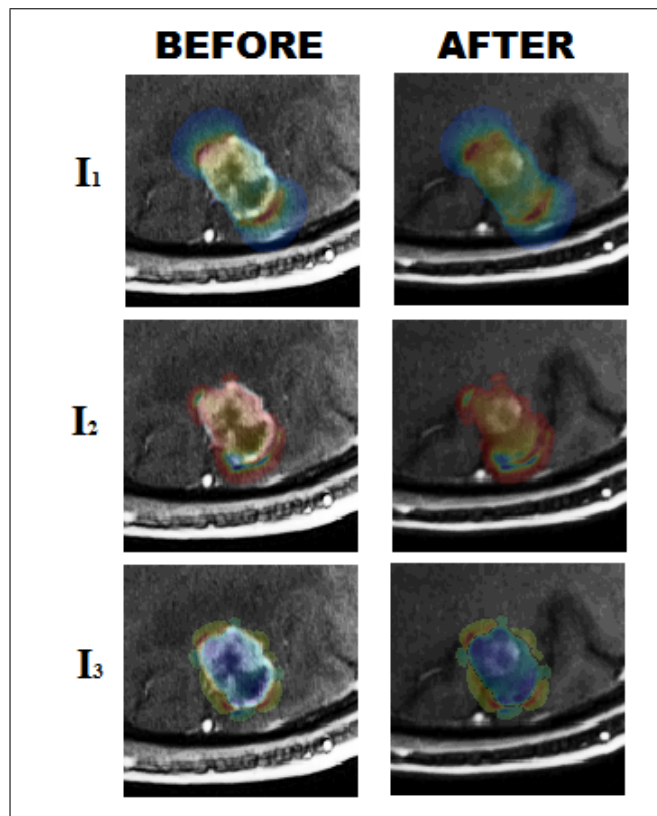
Visualization of the calculated tensor invariants on the MR images acquired before (left column) and after (right column) the therapy.
